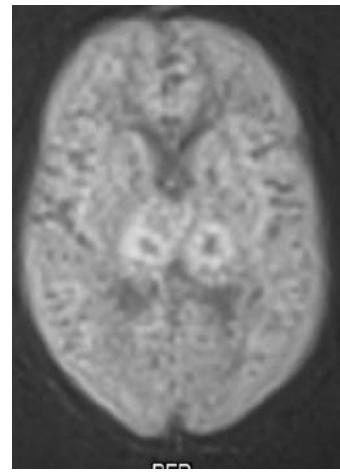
Diffusion-weighted MRI: bilateral symmetric hyperintense lesions with ring-like features in the thalami
